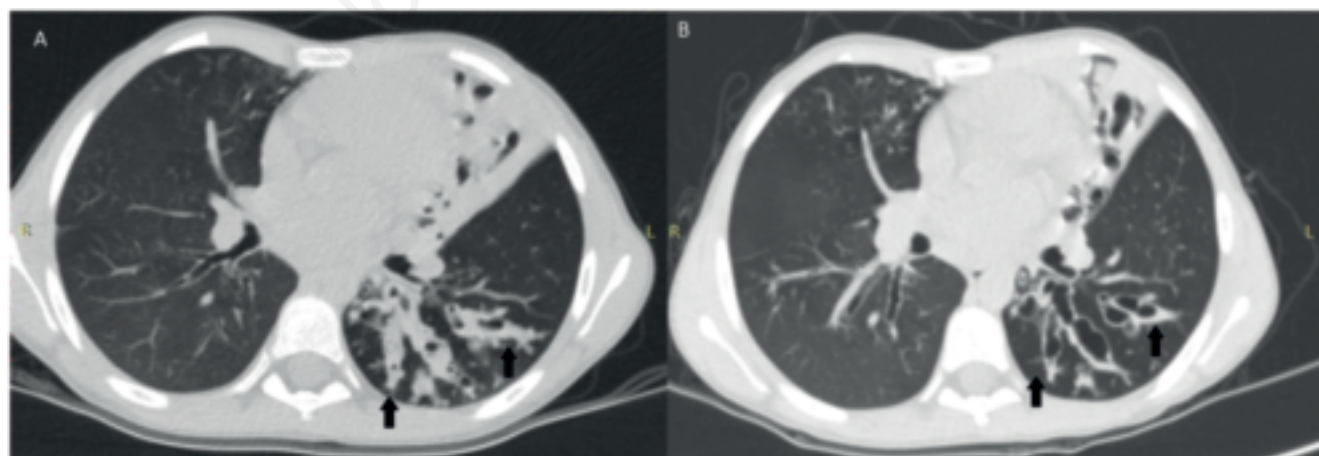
A) Axial image of the inspiratory computed tomography scan, we can see the mucus obstructing varicose bronchiectasis in the superior segment of the left lower lobe and atelectasis of the lower segment of the lingular lobe, with bronchiectasis filled with mucus; B) axial image of the inspiratory computed tomography scan of the same patient, at the same level as A, we can see cleansed, mucus-free varicose bronchiectasis in the superior segment of the left lower lobe and better cleansing of the bronchiectasis of the lower lingular segment.
